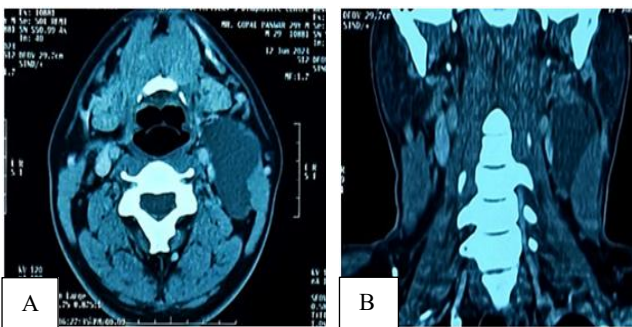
Contrast enhance computed tomography showing well- defined enhancing fluid density space occupying lesion in left submandibular region: (A) CECT axial cut and (B) CECT coronal cut.
